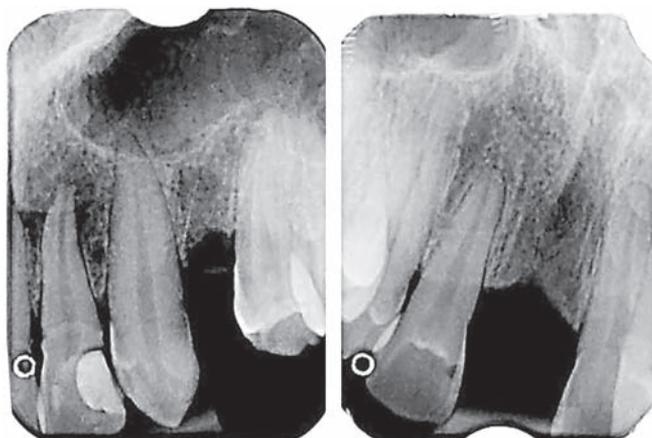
Radiolucency was seen at mesial aspect of crown suggestive of caries with tooth 12 and missing tooth 21. Radiopacity seen with 22 at distal aspect of crown suggestive of restoration, radiolucency was seen under radiopacity suggestive of secondary caries and periapical radiolucency suggestive of periapical lesion
